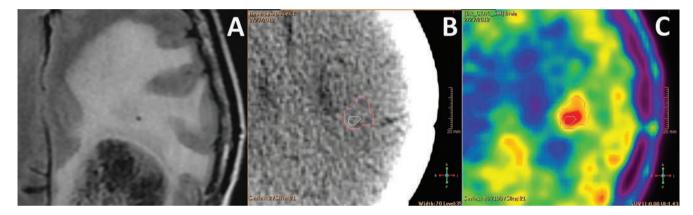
Patient after left-sided occipital craniotomy. (A) MRI images, (B) CT images, (C) 18F-FET-PET images
